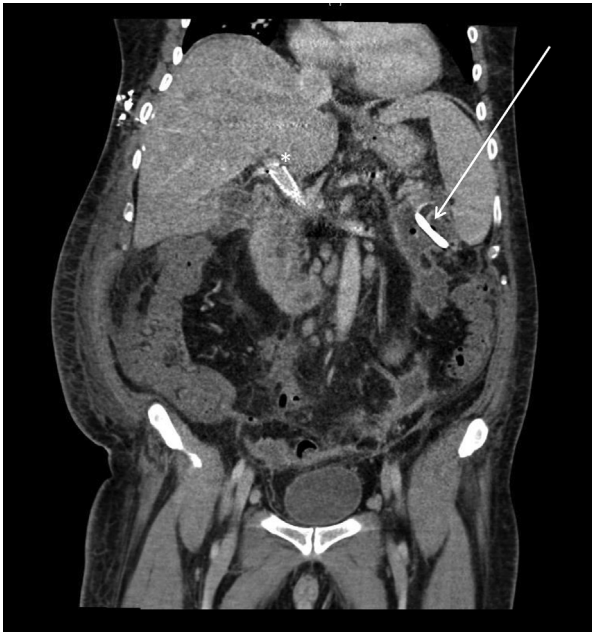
Coronal view of computed tomographic scan of abdomen showing peripancreatic abscess formation, course of inserted drainage catheter (arrow) and portal vein stent (asterisk).
